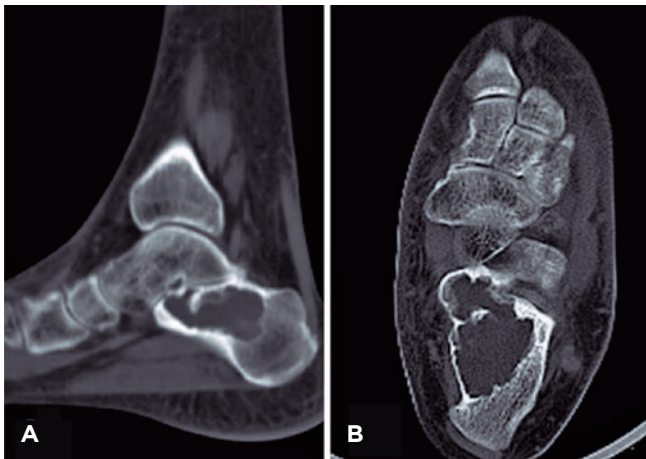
Computed tomography (CT scan). A) Sagittal section. B) Axial section suggestive of eccentric, expansile, lytic lesion with thinned out medial cortex and about to breach subtalar joint.
